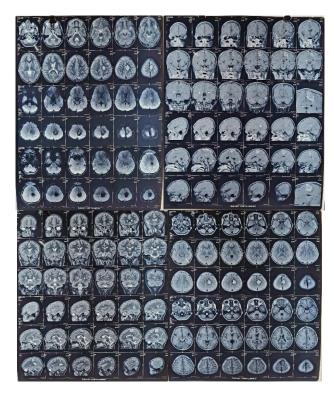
MRI brain (contrast) showing cavernous angioma in left high frontal lobe. There is no leptomeningeal enhancement.
